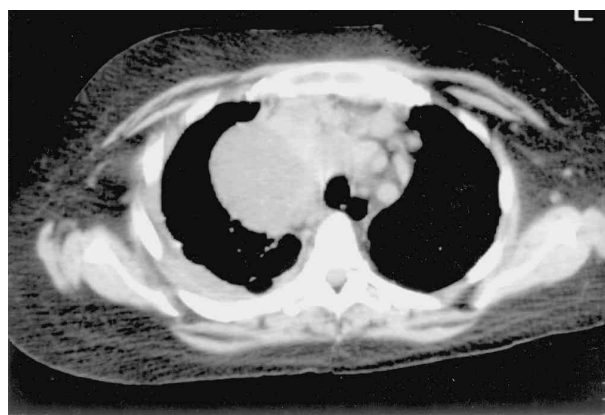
CT scan of the thorax showing right mediastinal mass.
